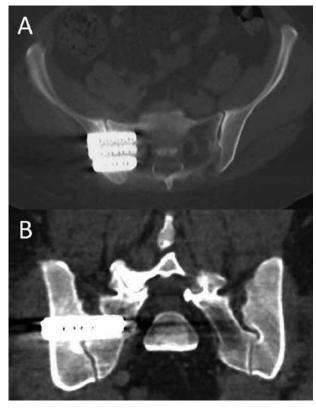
Abdominal CT with axial (A) and coronal (B) views showing bony narrowing of right S1 foramen during patient emergency department visit after initial SIJF
